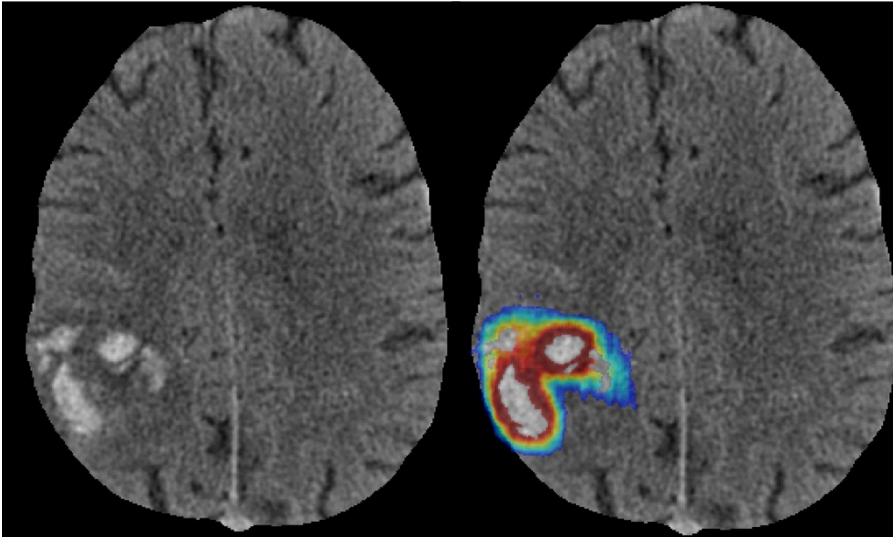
Non-contrast CT image slice and resulting perihematomal edema probability map
